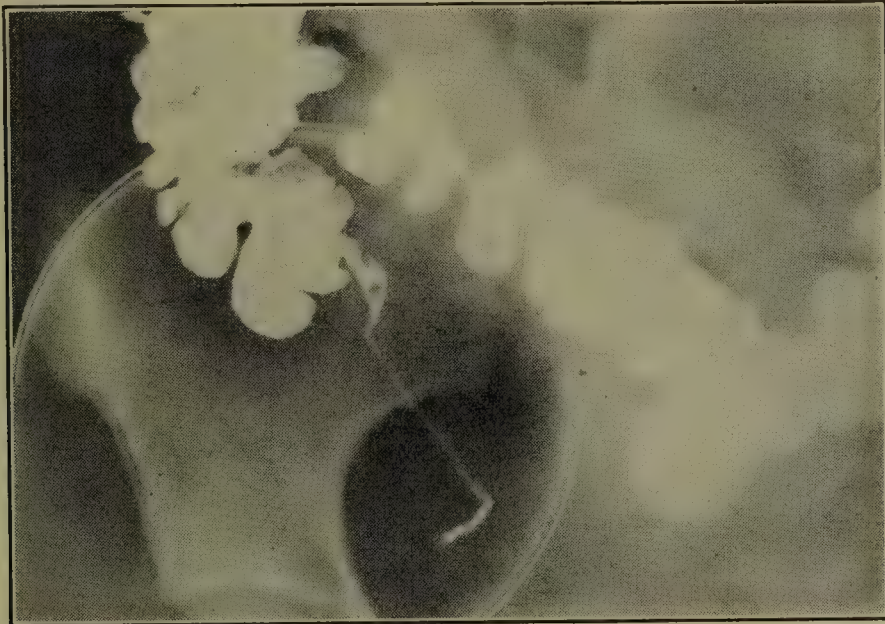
RADIOGRAPH SHOWING CECUM AND UNUSUALLY LONG VERMIFORM PROCESS, EXTENDING INTO THE PELVIC CAVITY. (Dr. R. D. Carman, Mayo Clinic.)
